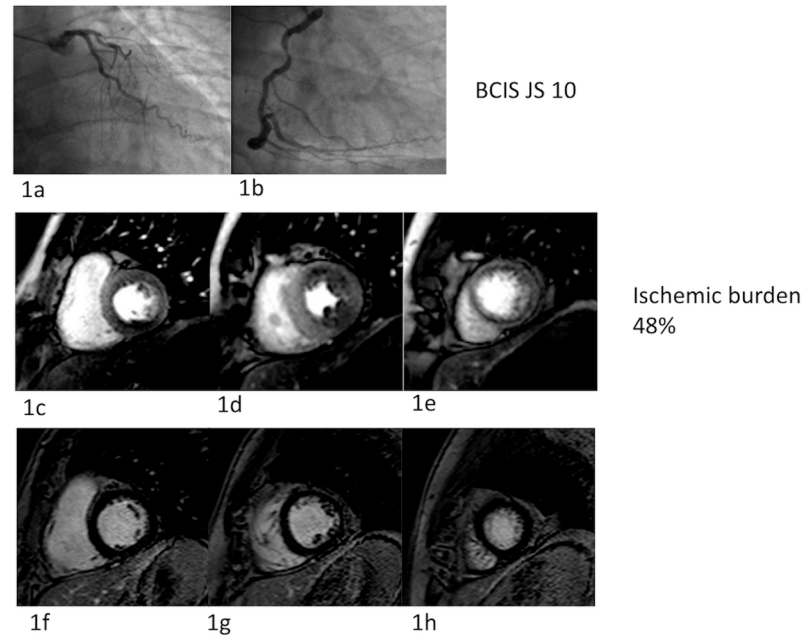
X-ray coronary angiogram and CMR stress perfusion and scar imaging from one patient.
